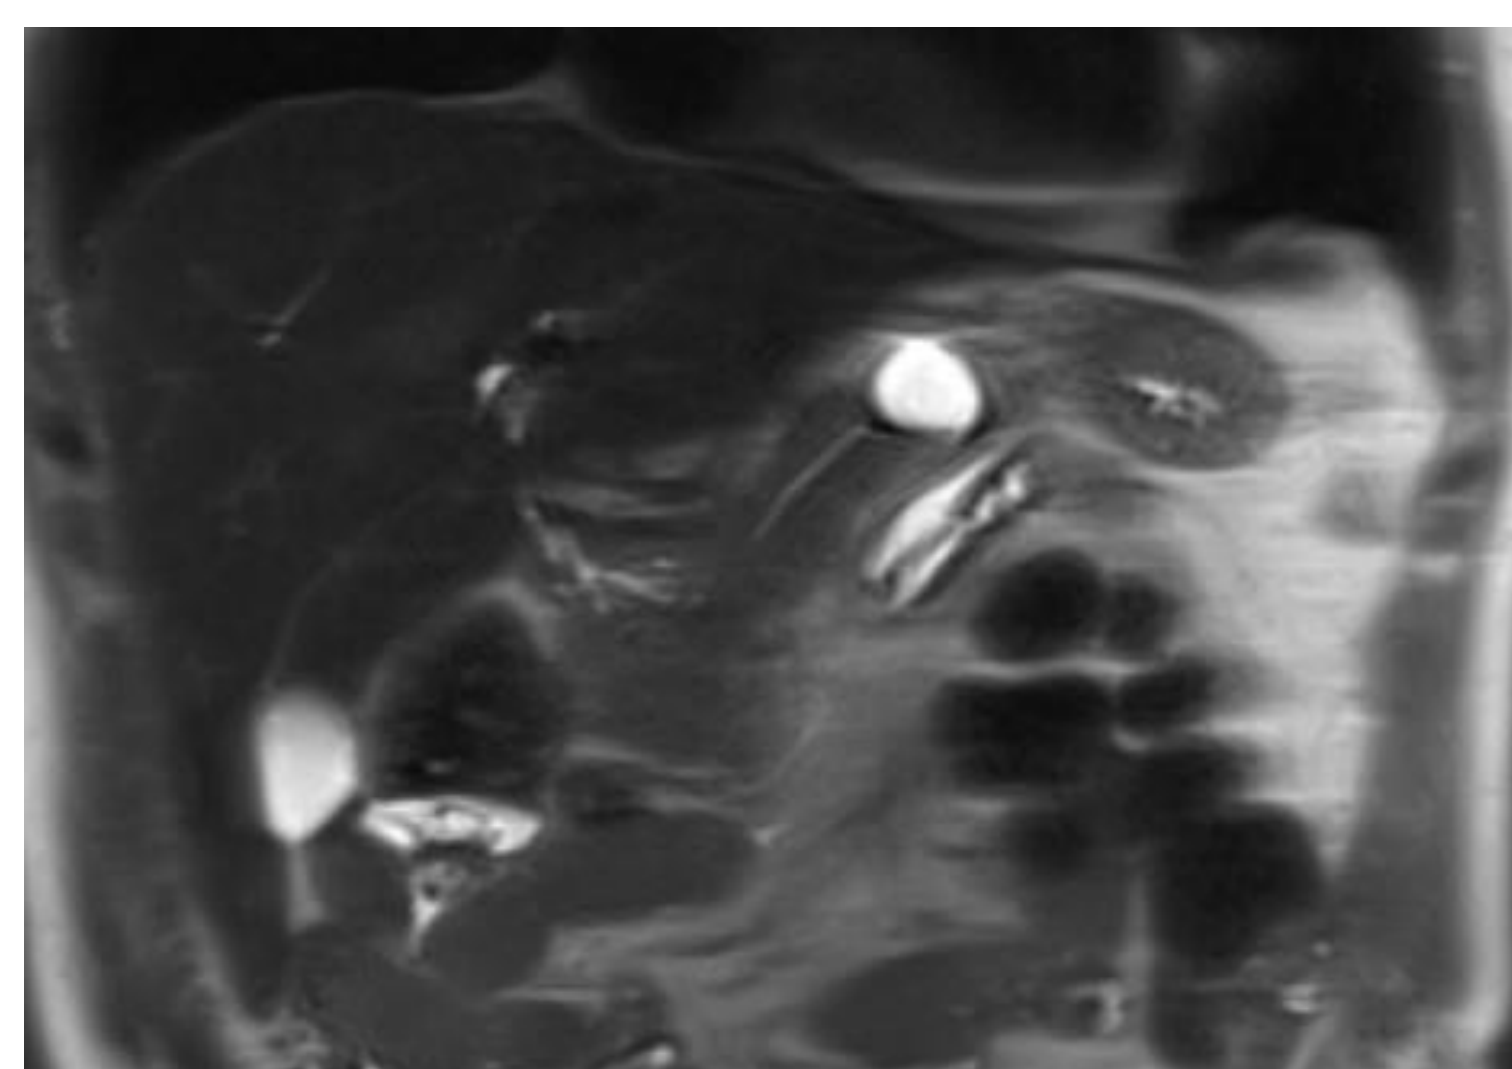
MRI Abdomen Pancreatic cyst.
